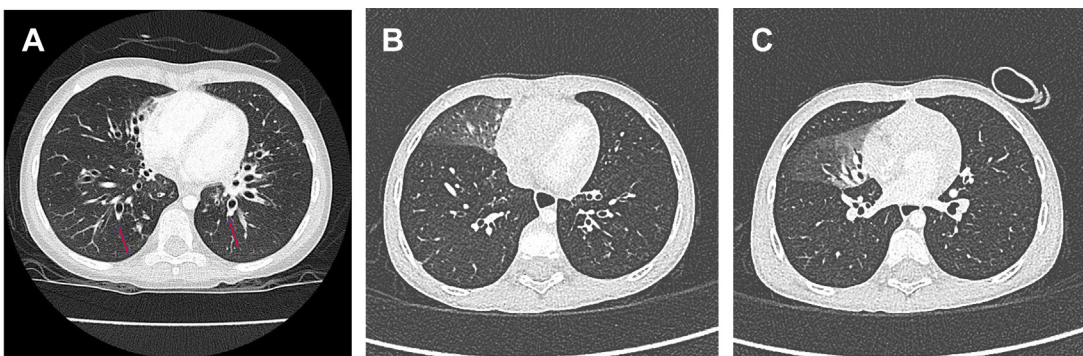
Chest CT scan findings in bronchiectasis. (A) Chest HRCT scan image of a 4-year-old child with bronchiectasis. She presented with a history of recurrent pneumonia and had finger clubbing. Note dilated airways in both lower lobes. The bronchoarterial ratio is compared between the inner diameter of the airway with the outer diameter of the adjacent artery along the short axis, present within 1 mm of distance to each other. Note the classical "signet ring" or "pearl ring" appearance of various airways (arrows). If the airway and artery are oblique, that is, the ratio of the largest diameter and the smallest diameter is greater than 1.5, they should not be considered. (B) HRCT scan image in a 29-month-old child with a history of recurrent wet cough. Note dilated airways in both lower lobes. (C) HRCT scan image of the same child in 2-B showing atelectasis and dilatation of airways in the right middle lobe.
